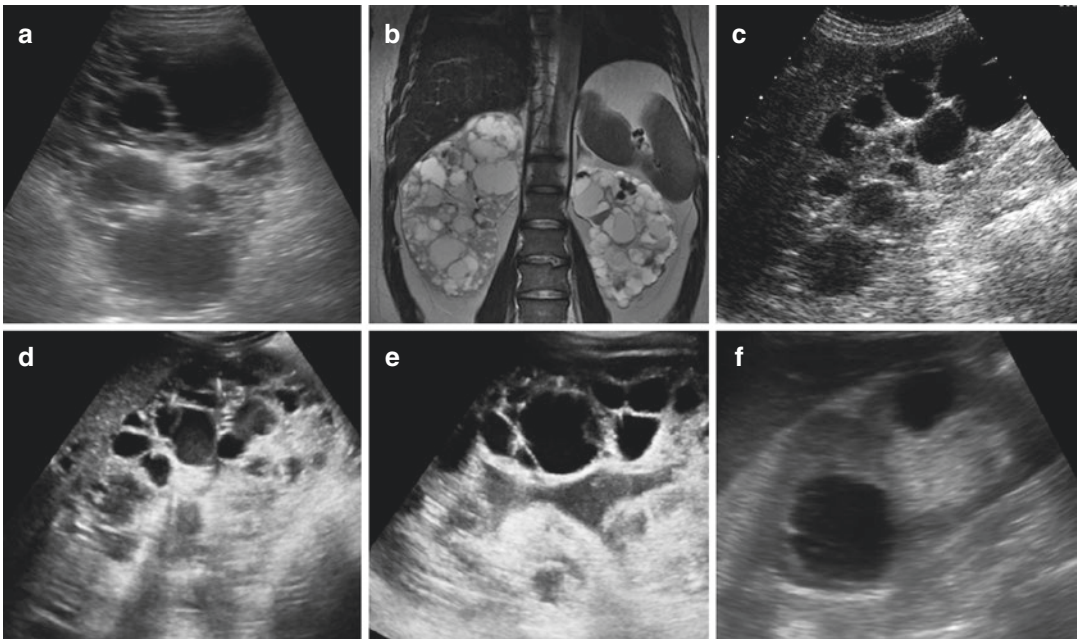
(a) Cystic dysplasia. Marked enlargement of the kidneys with multiple cortical, medullary cystic lesions of various dimensions and loss of the renal cortex. (b) MRI. T2-weighted images in coronal plane. (c) Cystic
